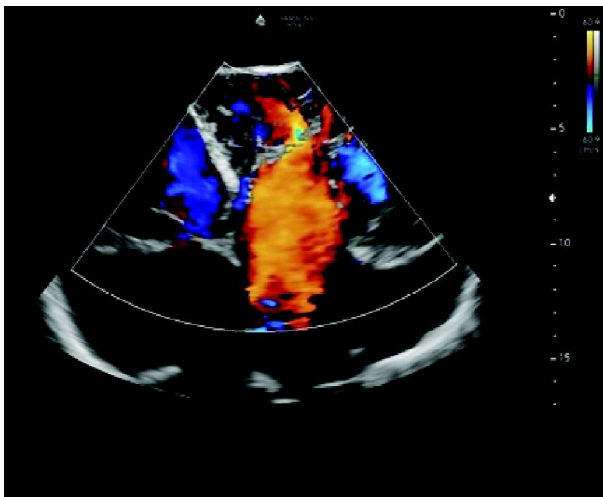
Echocardiography showing blood flow into intertrabecular recesses.
